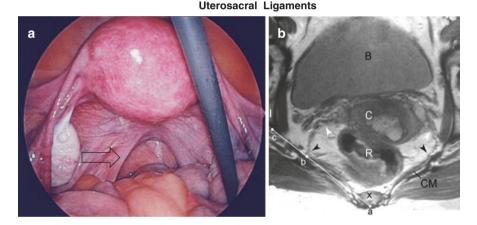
(a) Photo: Transparent arrow indicates the uterosacral ligament complex (Photo Courtesy Peter Cole, M.D.) (b) MRI of uterosacral ligament insertion: The origin of the uterosacral ligaments from the cervix (*white arrowheads*) and their insertions (*black arrowheads*) on the pelvic sidewall. The location of the insertion point (*b*) on a line (*ac*) between the body midline and the ischium (*I*). The location of the bladder (*B*), cervix (*C*), rectum (*R*), coccyx (*X*), and coccygeus muscle (*CM*) are shown (Image 1 in Umek et al. [11])
